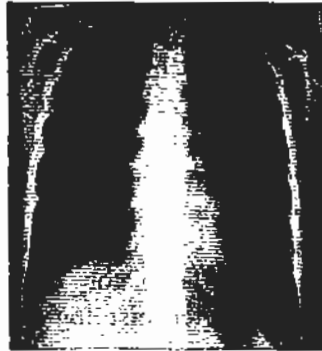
Repeated chest X-ray after treatment showed improvement
